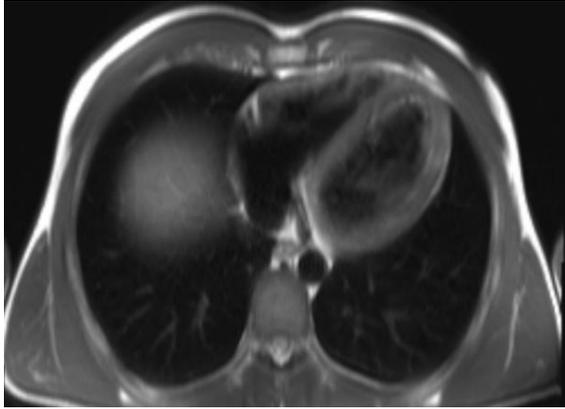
The cardiac magnetic resonance imaging shows subendocardial enhancement in the inferoposterior wall of the left ventricle.
